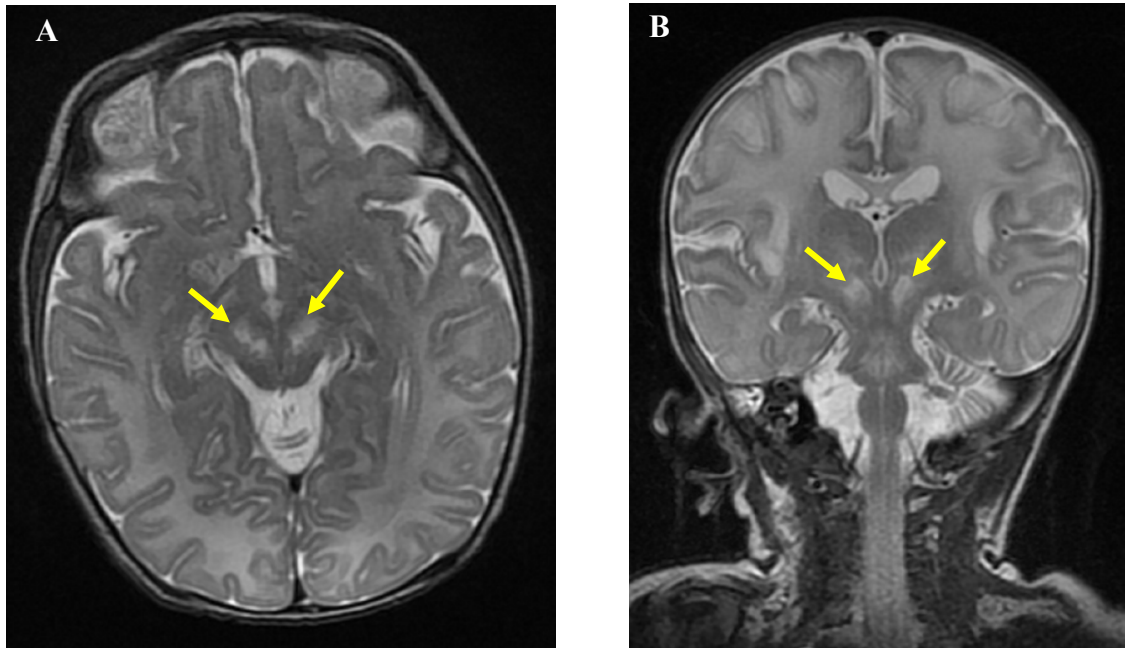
Brain MRI neuroradiological images for Patient 2
